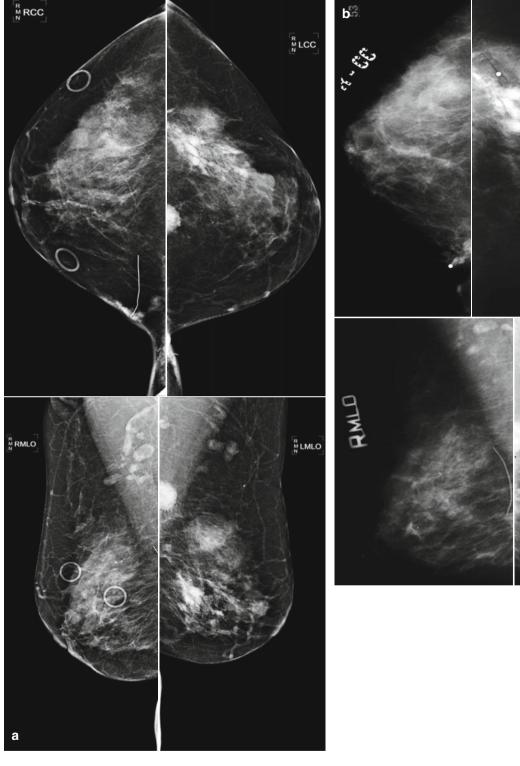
(a) A 50-year-old female with history of ruptured silicone biopsy was performed with pathology yielding invasive ductal carciimplants. Physician detects palpable abnormalities in the upper outer noma. (e) Post-procedure mammogram documents a clip in the mass in and lower outer left breast and upper inner right breast. (b) An outside the upper outer breast. Note the higher density of the silicone granulomammogram from 2 years prior shows no significant change in highmas. (f) Axial MRI silicone-sensitive sequence demonstrating high sigdensity masses in area of free silicone. (c) Multiple silicone granulomas nal in one of the silicone granulomas. Note the absence of increased documented in both breasts on ultrasound. (d) However, ultrasound of signal in the area of known cancer in the posterior outer breast. Postthe area of palpable complaint documents a 1.6 cm hypoechoic mass contrast T1 images with fat saturation show enhancement in the known that is different in appearance from the silicone granulomas and has cancer and no enhancement in the area of the silicone granuloma sonographic features of malignancy. Ultrasound-guided core needle
